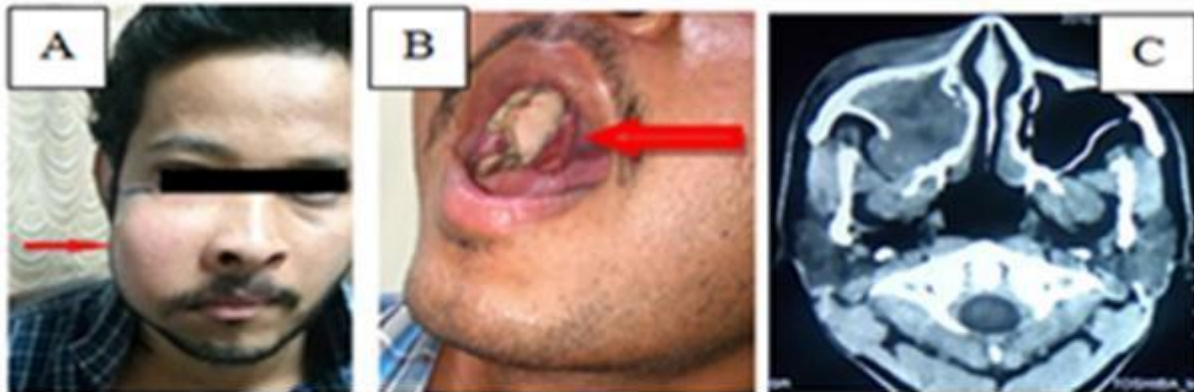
A and B: Picture of the patient at presentation showing right cheek swelling and right upper alveolar growth. C: Computed tomography Scan demonstrating a right Maxillary enhancing mass, infiltrating surrounding structures.
